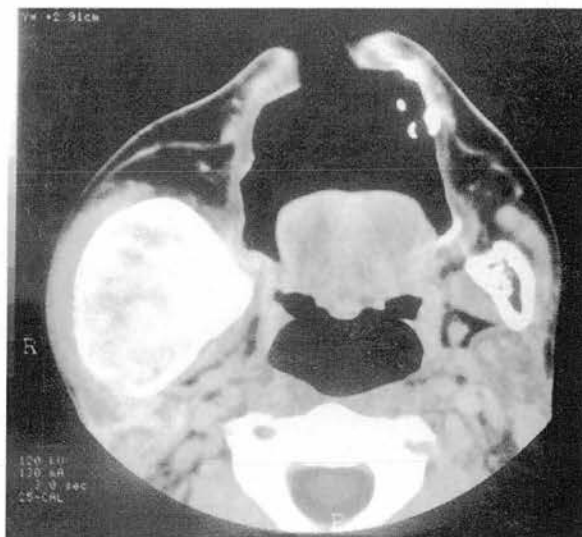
A soft-tissue window of an axial CT section of FD affecting the vertical ramus of the mandible. It expands the vertical ramus greatly in all directions; this expansion is remarkable on comparison to the normal contralateral side. This substantial expansion of the vertical ramus is accompanied by hyperplasia of the masseter muscle.
